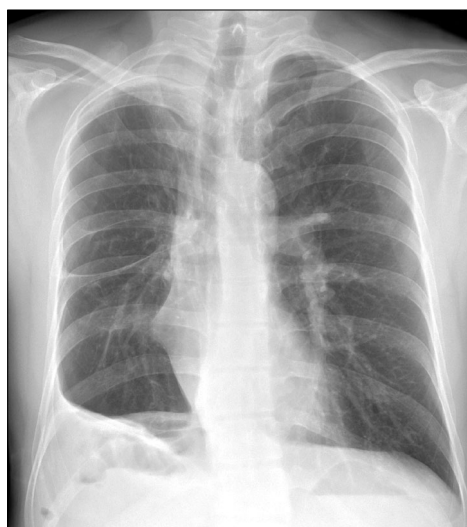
Chest X-ray shows the improvement of left-sided inguinal hernia after the operation (1-month after the operation).
